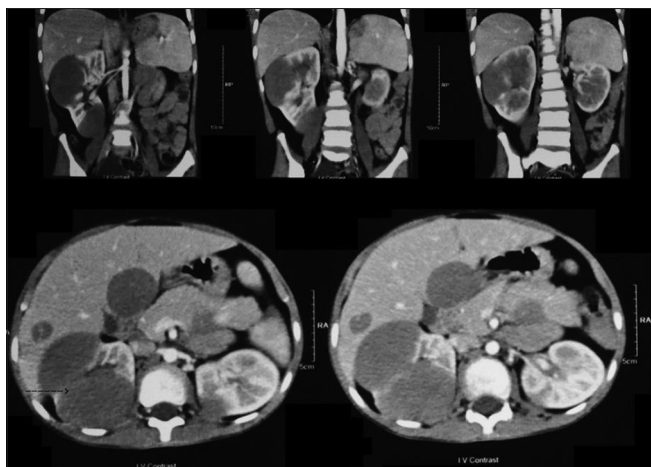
Contrast-enhanced computed tomography scan of the abdomen revealed poorly enhancing, hypodense bilateral renal masses ranging from 4 cm to 5 cm in size along with multiple hepatic and pancreatic space occupying lesions. A 4.3-cm exophytic mass was noted in the lower pole of right kidney
